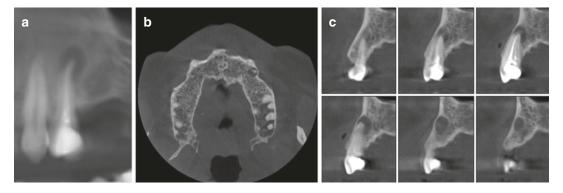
Cone beam CT examination of the same patient. Panoramic (a), axial (b), and cross-sectional images are showing a well-defined radiolucent apical
